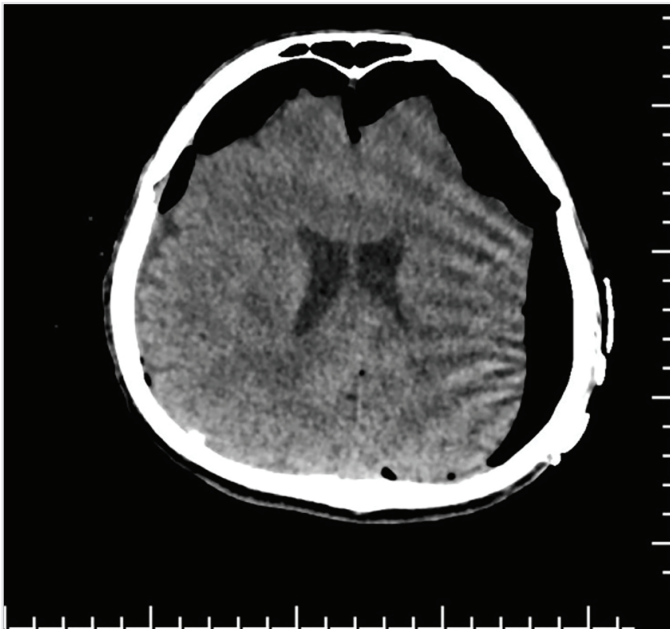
Postoperative axial computed tomography imaging in the parenchymal window after the burr hole technique for the evacuation of subdural hematoma. Widespread air densities consistent with pneumocephalus were observed in the subdural space. The Mount Fuji sign is in the left frontal region
